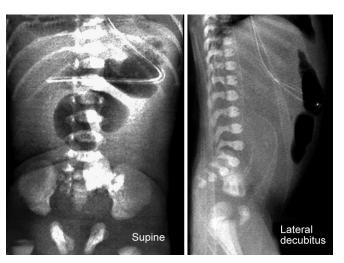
Jejunal atresia. Plain X-ray in supine and lateral decubitus views. Only proximal loops are dilated with no distal gas
